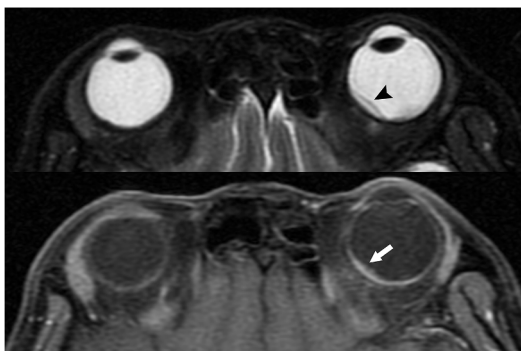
Axial T2-weighted fat-suppressed (top) and fat-suppressed gadolinium-enhanced T1-weighted (bottom) MR sequences in a patient with breast cancer demonstrates a left choroid metastasis appearing as a curvilinear enhancing lesion at the posterior choroid (white arrow) with associated subretinal fluid (arrowhead).
